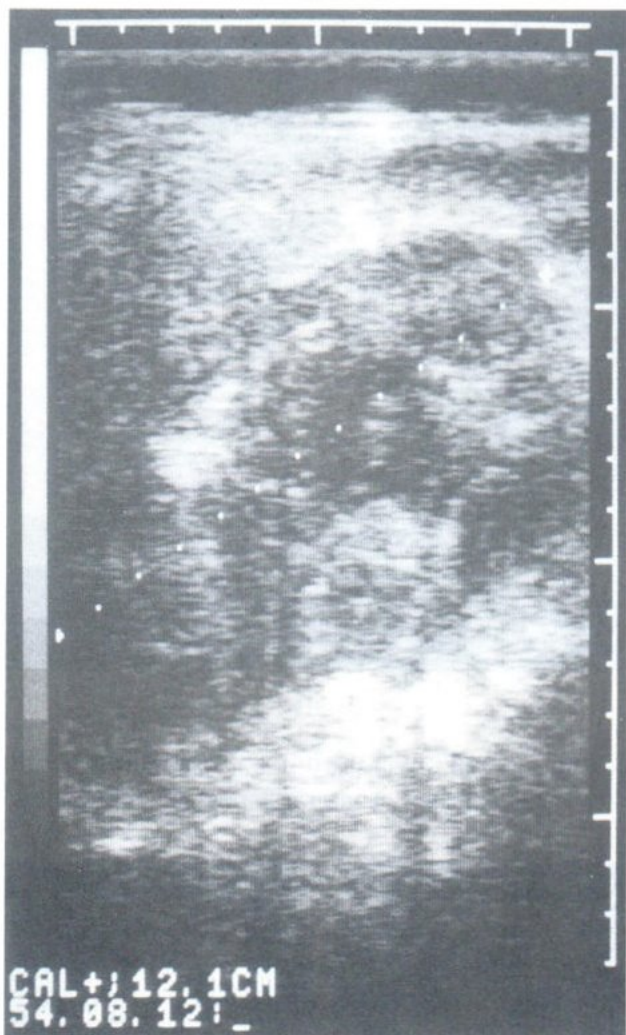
Renal ultrasonography of right kidney shows a large mixed echogenic mass with dense internal echoes involving mid and lower portions with upper pole sparing.
